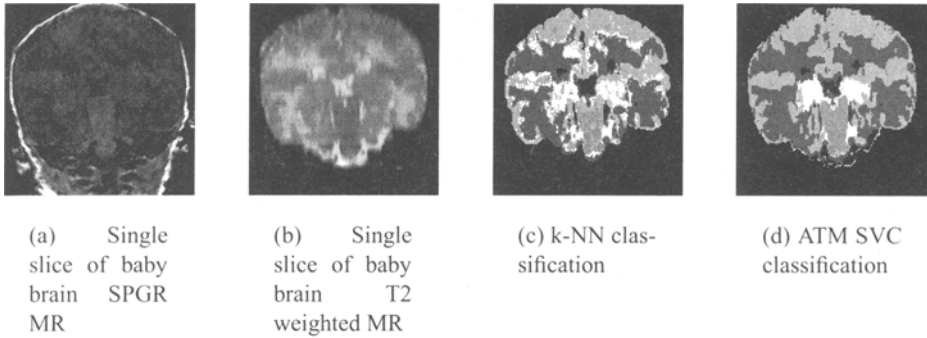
MRI of baby brain, k-NN classification and ATM SVC segmentation. Cortical grey matter is shown in light grey, and subcortical grey matter is shown as white. The quantification of cortical grey matter is a clinically important problem, but it is difficult to distinguish from subcortical grey matter because of the similarity of MR intensity. The ATM SVC algorithm allows the spatial distribution of grey matter to be modelled, and as shown, generates an improved segmentation of cortical and subcortical grey matter over that of k -NN classification alone.
